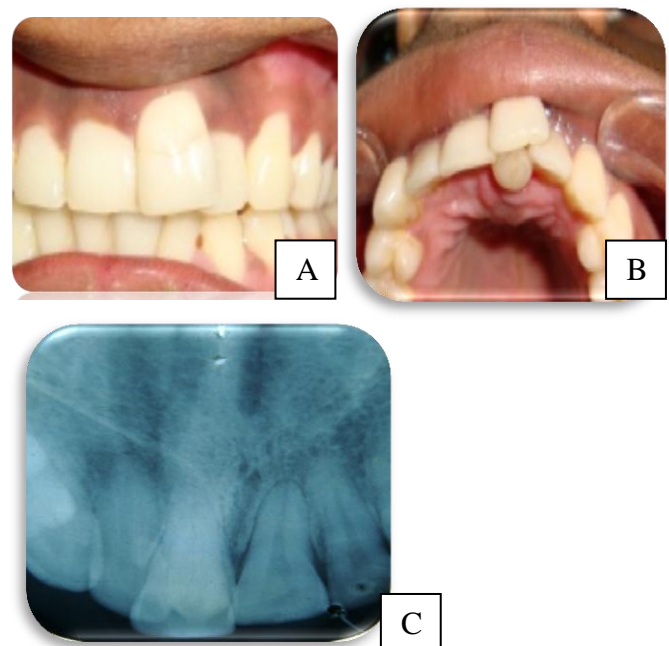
Preoperative facial view (A), Occlusal view (B) and Radiograph (C) of left central incisor tooth.
